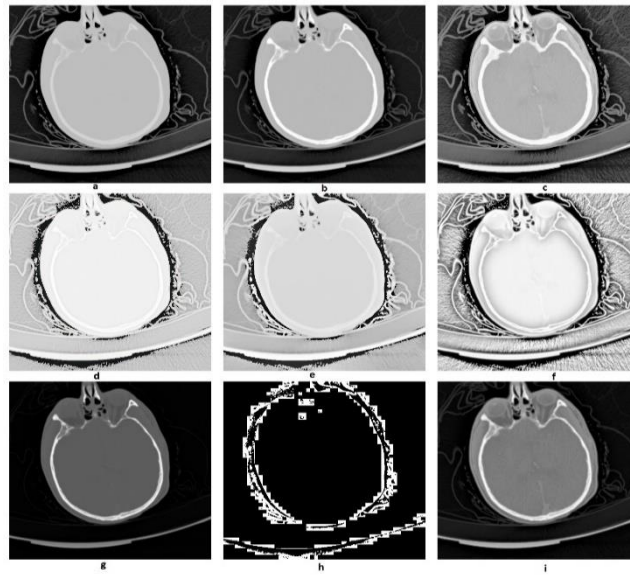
Enhanced test CT image of Head by (a) Reinhard (b) Kim (c) Khan (d) Li (e) Liang (f) Shibata (g) Al-Ameen (h) Gandhamal (i) Proposed, in the reading order.
